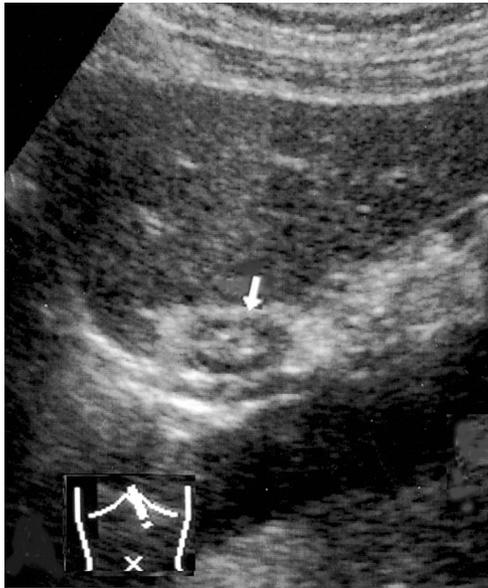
Sonographic patterns of the GE junction. A cross-section of the abdominal esophagus is seen behind the left lobe of the liver as a “small kidney” pattern in a healthy subject.
